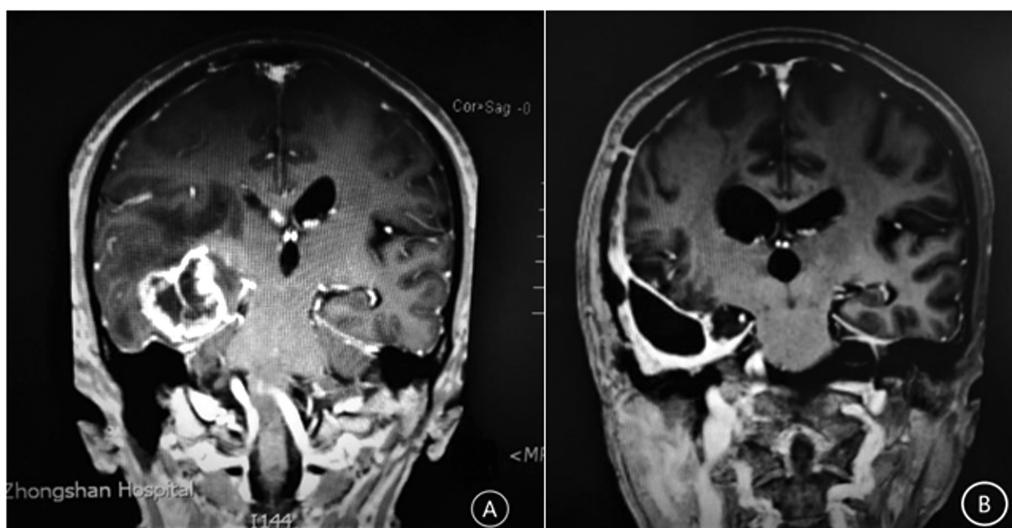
颞叶内侧胶质瘤手术前后 MRI 增强表现
